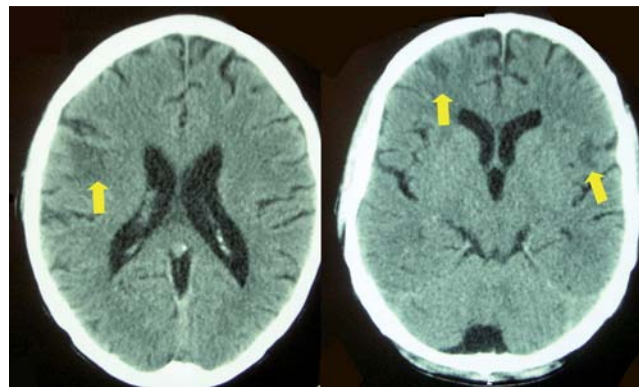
A computed tomography scan of the brain demonstrated three cortical-subcortical lesions (arrows), two of them involving the right frontal lobe and another one measuring 1.4 cm in the left Sylvian fissure, surrounded by edema.
